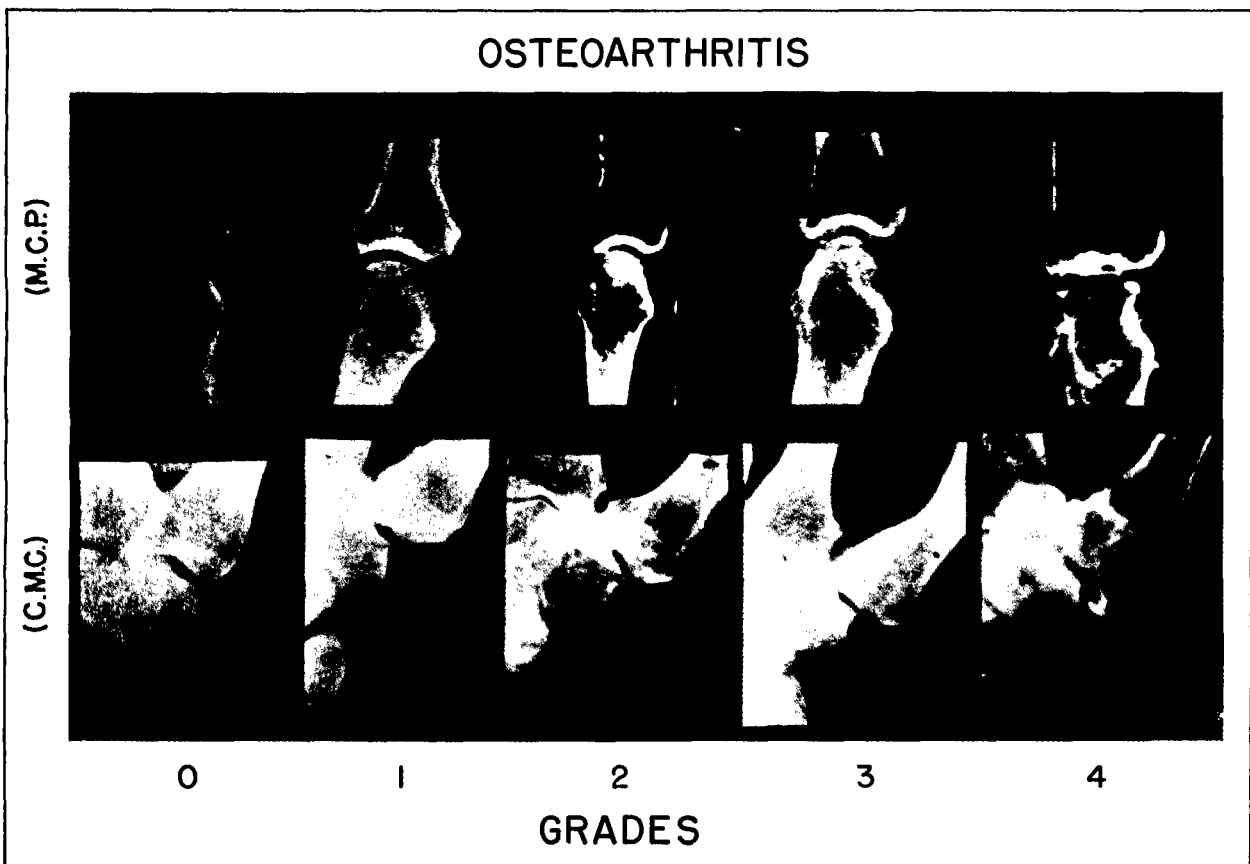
Gradings of osteoarthritis in metacarpophalangeal (M.C.P.) and carpometacarpal (C.M.C.) joints of the hands. Radiograph series from the Clinical Center, National Institutes of Health used in the Health Examination Survey, Cycle I.
